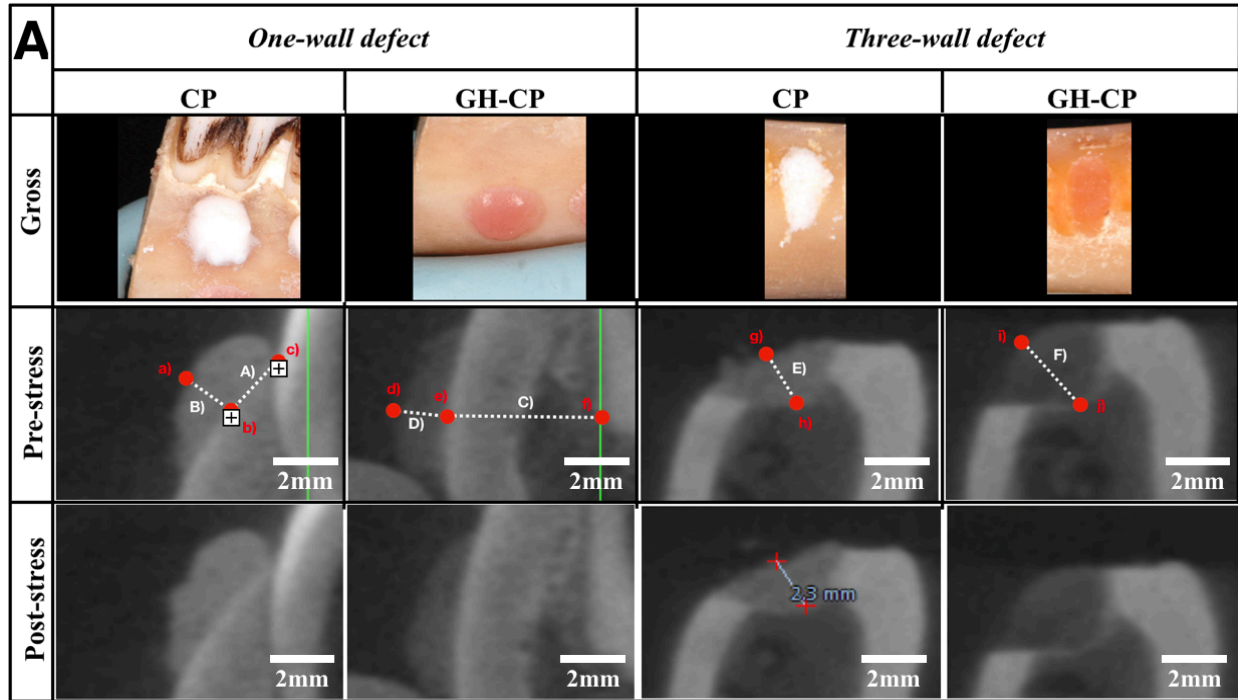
(A) Comparative CBCT volumetric deformation images in one or three-wall defects; (B) Deformation ratio (%): Two-way ANOVA, followed by Tukey's post-hoc test, $n=4$, mean \pm S.D., * p -value $< .05$,  p -value $< .01$.
